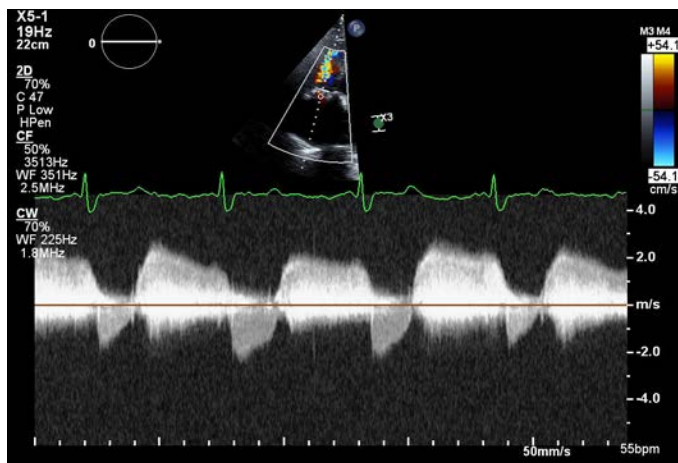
Continuous Wave Doppler of the bioprosthetic tricuspid valve. Note the prolonged diastolic filling time with flattened velocity profile, consistent with valvular stenosis. The mean diastolic gradient is 15 mmHg and pressure-half time is 456 ms.
